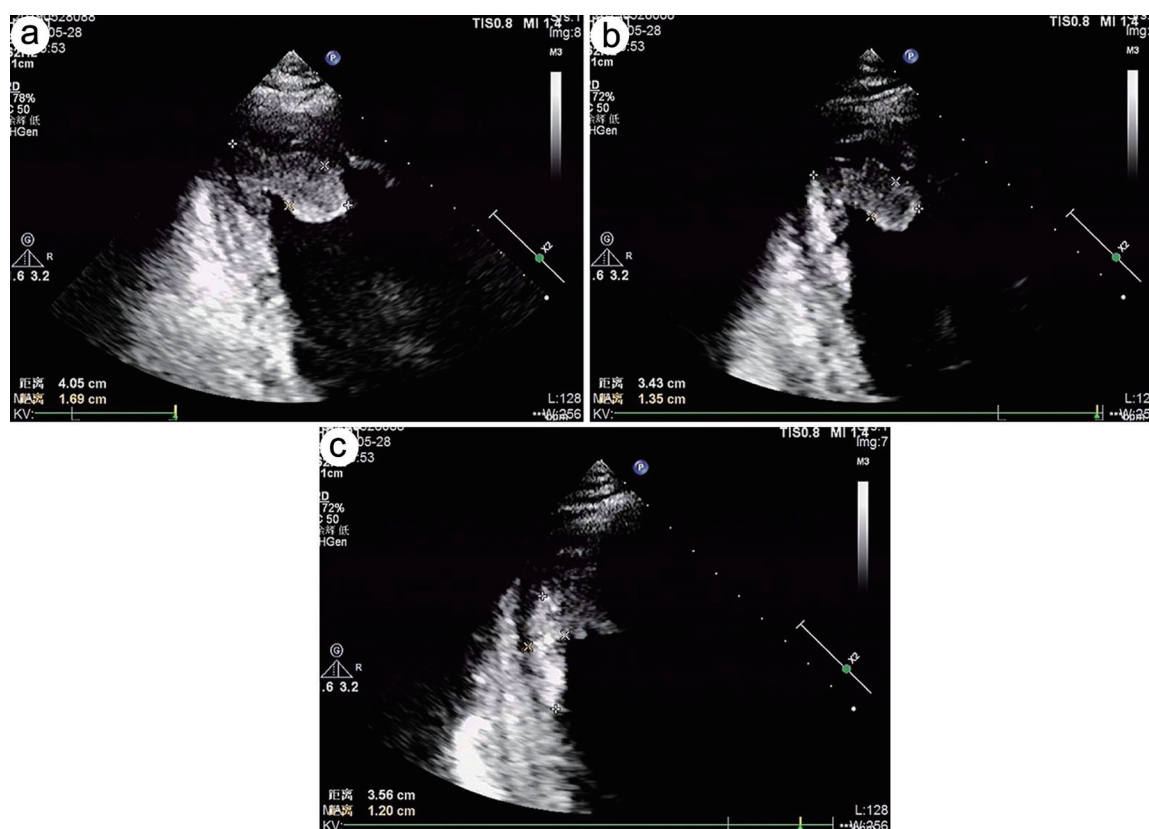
Admission UCG of case 1. UCG, ultrasonic cardiogram.
